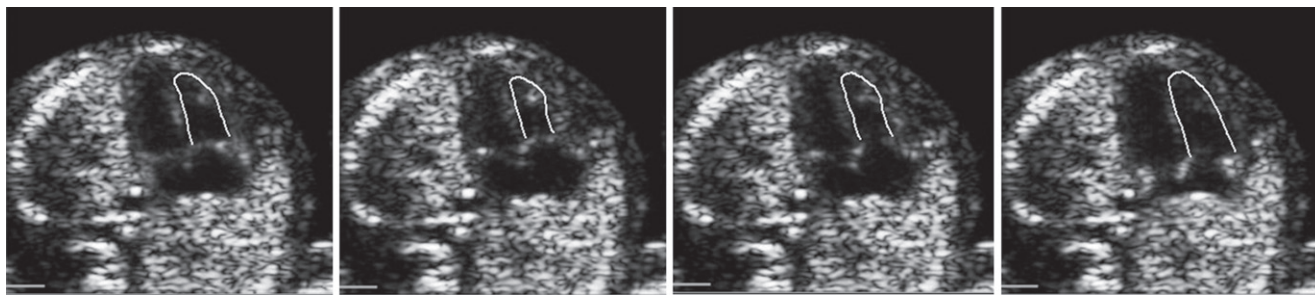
Ultrasound images of the four-chamber view of the fetal heart at 12 weeks' gestation showing automatic tracing of endocardial borders by vector velocity imaging software during different phases of the cardiac cycle.
